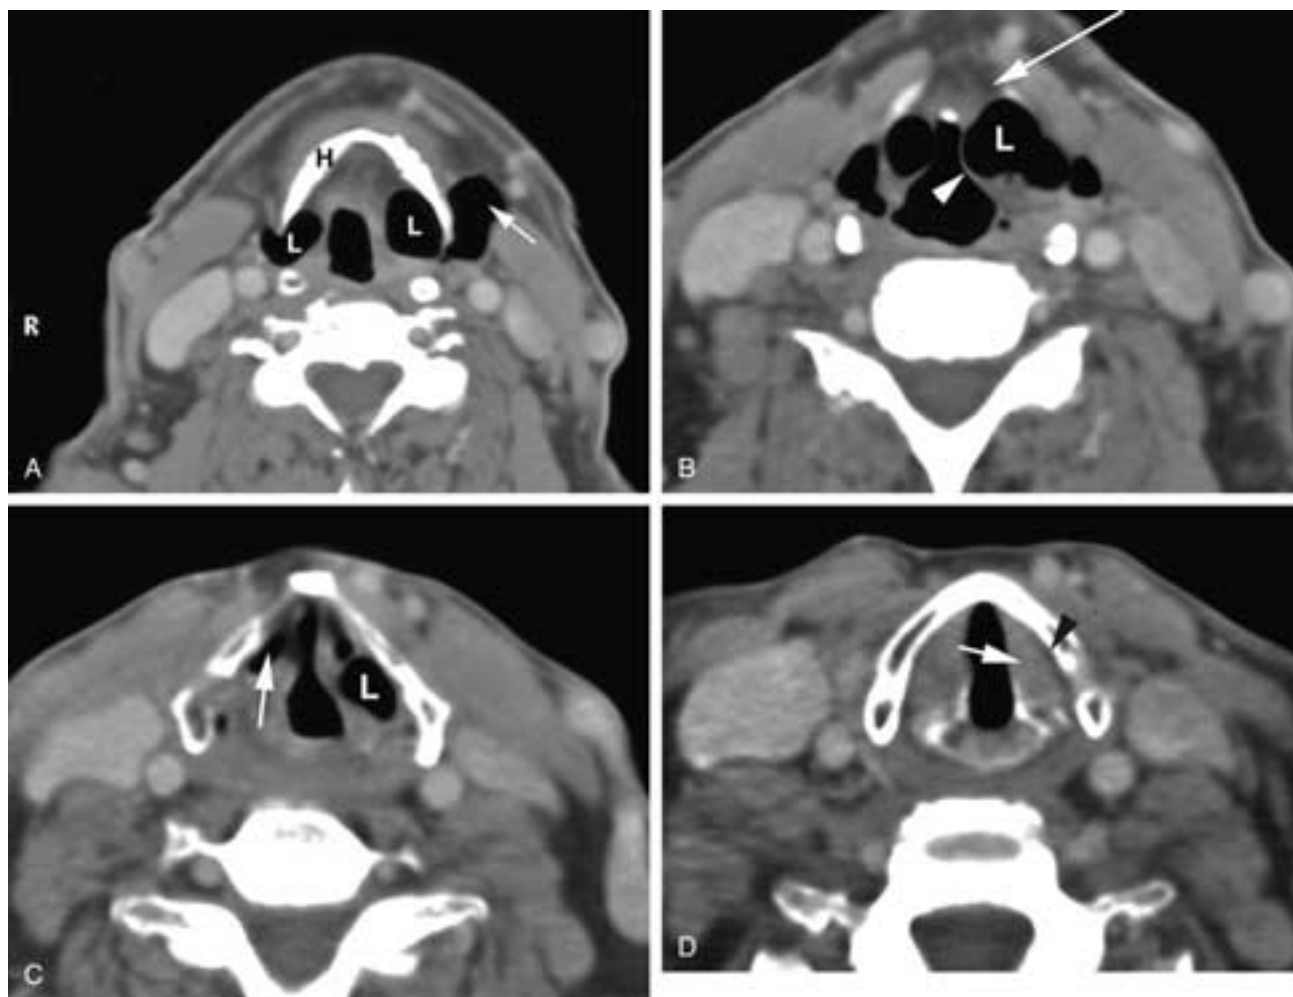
Bilateral air-filled laryngoceles. Axial CT. A, The laryngoceles (*L*) are bilateral. On the left, there is extension between the hyoid bone and the thyroid cartilage into the lateral soft tissues (*arrow*). This is a combined internal/external laryngocele. Hyoid bone (*H*). B, Slightly caudad slice shows the bulge of the mucosa (*arrowhead*) at the supraglottic level. Laryngocele (*L*); intact contiguous paraglottic and preepiglottic fat (*arrow*). C, Caudal to B. The laryngocele (*L*) can be followed anteriorly (*arrow*) as the dilated appendix approaches the ventricle. D, The true cord level of the TAM (*arrow*) is identified. Note the crease of fat (*arrowhead*) along the lateral aspect of the muscle representing the inferior extent of the paraglottic fat. The fat is normal.
